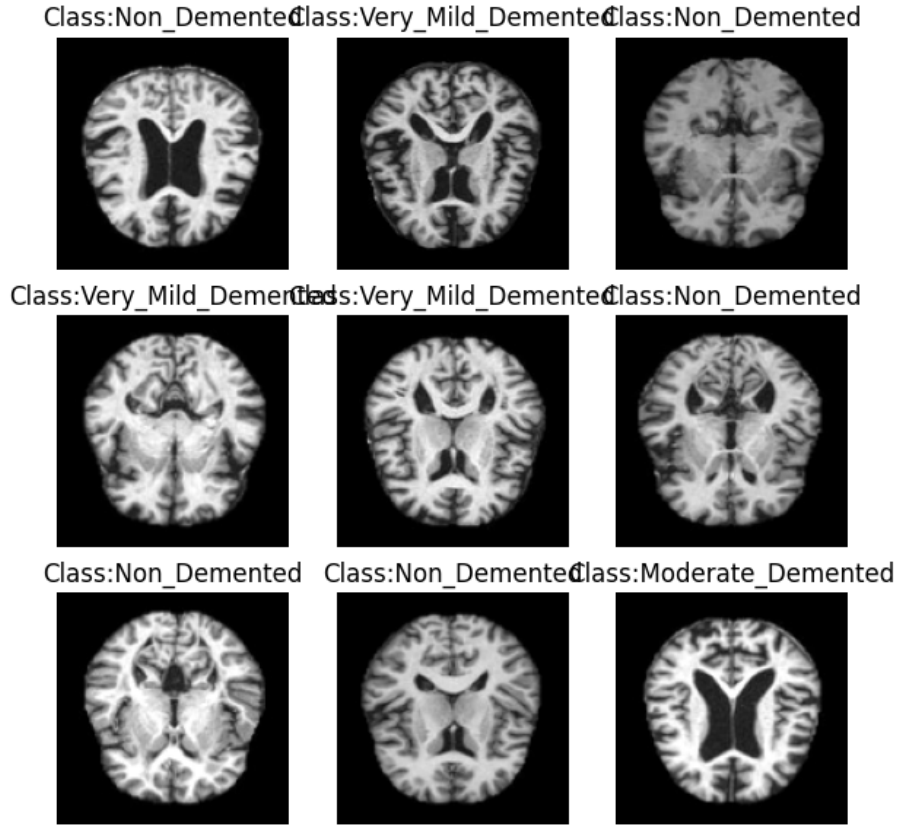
Sample MRI Images from MRI Dataset
